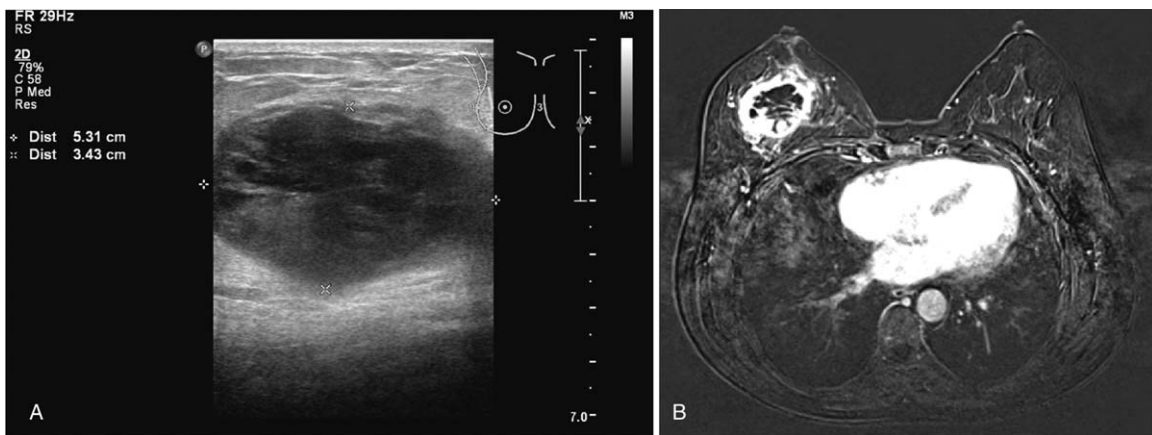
Preoperative images of the primary tumor. A, A transverse sonogram shows a complex cystic lesion in the patient's right breast. B, T2-weighted MR image shows a cystic mass in the patient's right breast, with significant enhancement after the injection of an enhancing agent. MR = magnetic resonance.
